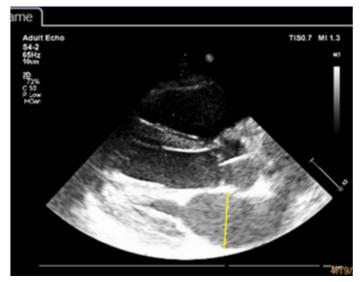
Bidimensional echocardiography. Parasternal long axis. Measurement of the LA diameter during atrial systole (opened mitral valve).
